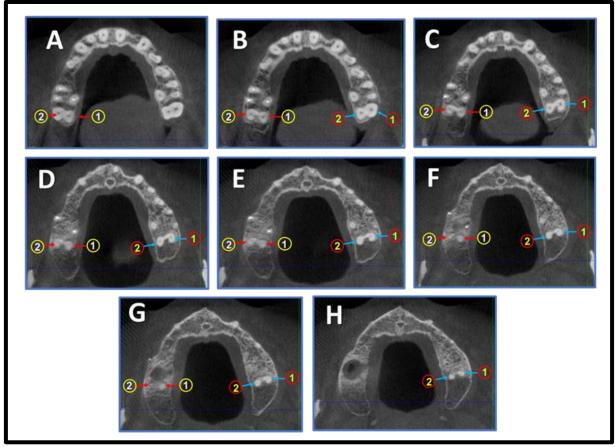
(A to H) Demonstrate the evaluation procedure of a Full CBCT image of bilateral maxillary double rooted wisdom teeth.
